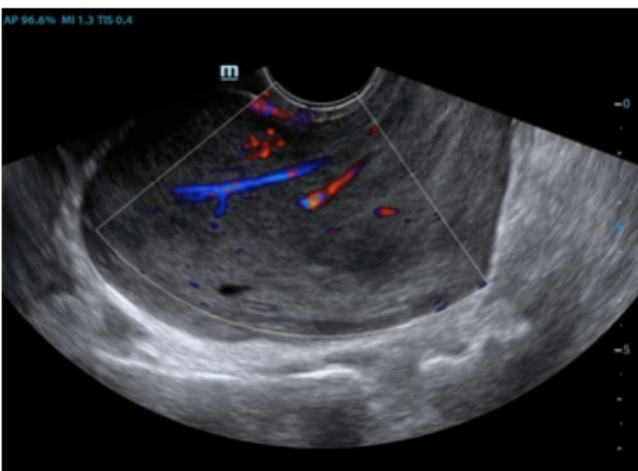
Transvaginal and Transperineal ultrasound showing showing well defined homogenous lesion with traversing vascular channels (Left) and isoechoic mass lesion arising from right vaginal wall near anal sphincter (Right).
